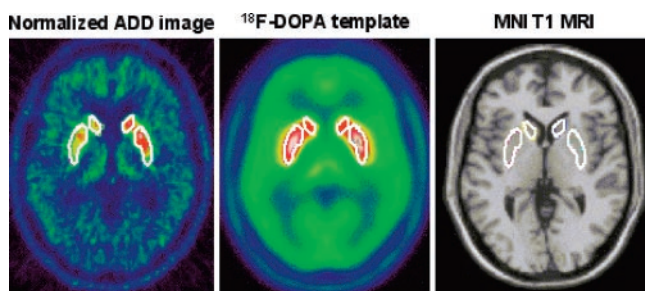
Template region object map (white outlines) overlying putamen and caudate nucleus bilaterally in normalized ADD (summed) image, ^{18}F -DOPA template, and single subject T1 MRI found in SPM99.
